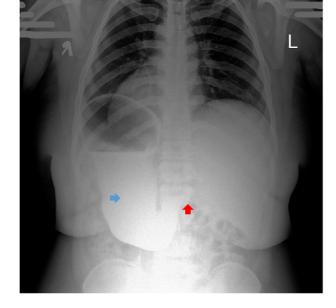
Barium meal radiograph showing a right-sided stomach (blue arrow) with the duodenum (red arrow) directed toward the left.
